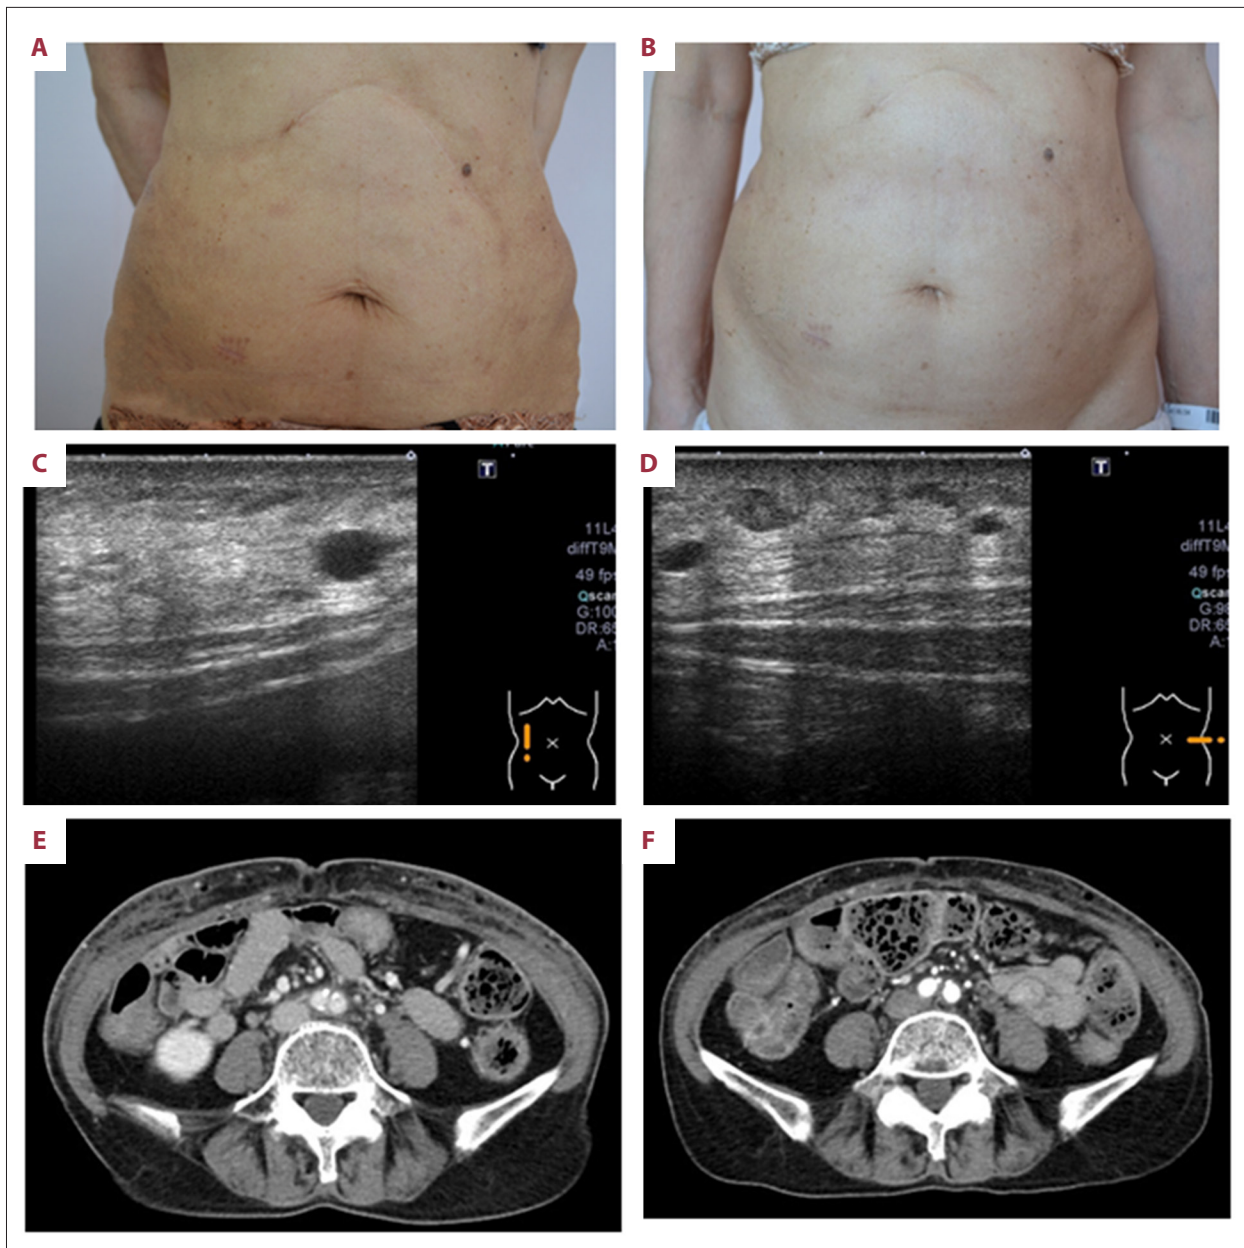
Photograph of the patient's abdomen and abdominal ultrasound and computed tomography (CT) scan images. Multiple subcutaneous indurations with hyperpigmentation in her abdomen can be observed at the time of admission (A). Photograph of the patient's abdomen 30 days after prednisolone therapy. Reduction of abdominal subcutaneous indurations as well as improvement in irregularities in the abdominal skin surface can be observed (B). Ultrasound of abdominal skin using a linear probe (C, D). CT image in transverse view obtained at the time of admission. A reticular shadow in the abdominal subcutaneous fat layer with fogging effect in the superficial fascial layer can be seen (E). CT image in transverse view obtained at one month after the administration of prednisolone. The abnormal findings saw undeniable improvement (F).
